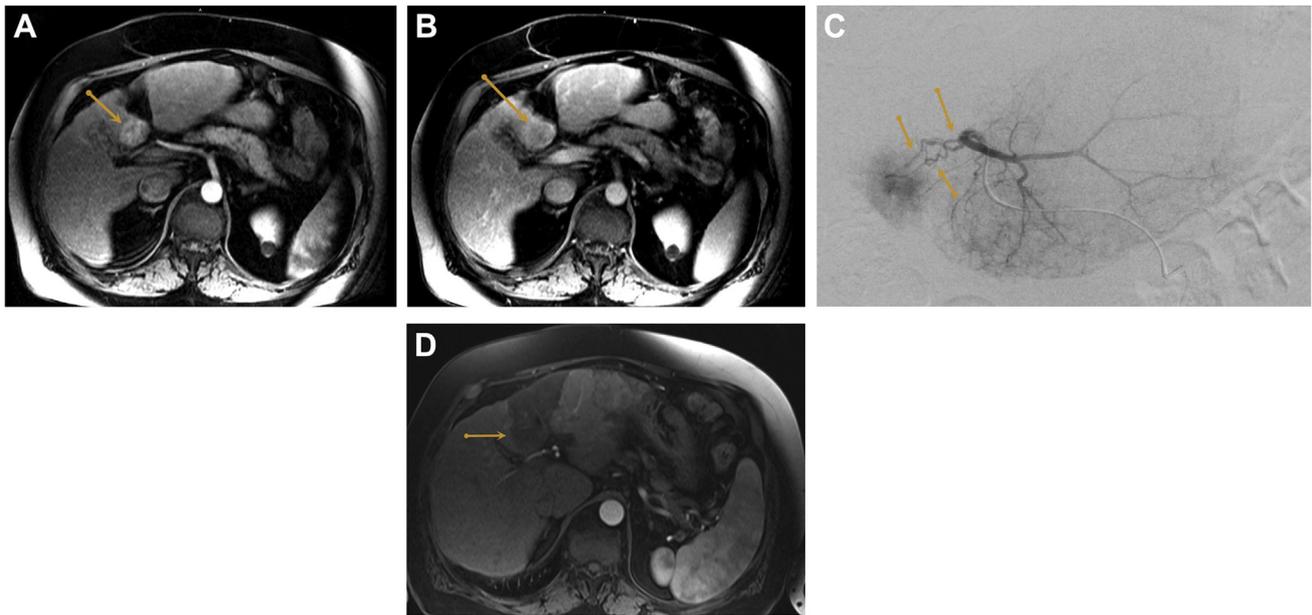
Axial magnetic resonance imaging (MR) T1-weighted images with contrast demonstrate a 3.3 cm mass enhancing in segment 4b demonstrating arterial enhancement (A) and washout on delayed phase (B) (arrows). (C) Catheter angiogram before infusion with ^{90}Y glass microspheres (TheraSpheres) showing arterial supply to the segment 4b tumor (arrows) and a portion of the left hepatic lobe. (D) Posttreatment contrast-enhanced T1-weighted MR images performed 4 months later show complete response without evidence of viable tumor (arrow).
